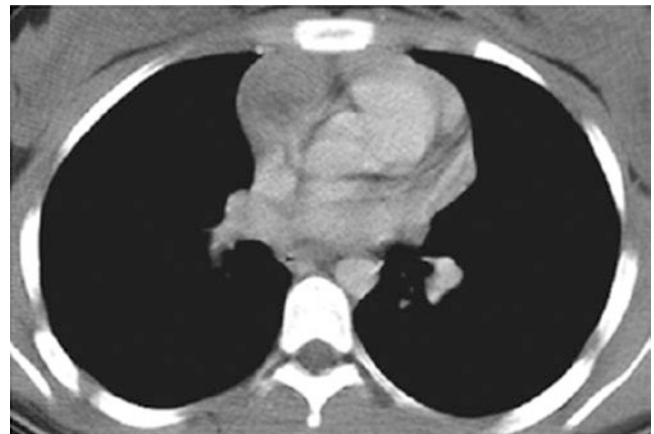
A 14-year-old girl with a noninvasive thymoma who presented with fainting spell and abnormal chest radiographs. Enhanced axial CT image shows a relatively well-circumscribed lobulated mass in the anterior mediastinum abutting the right anterior heart
